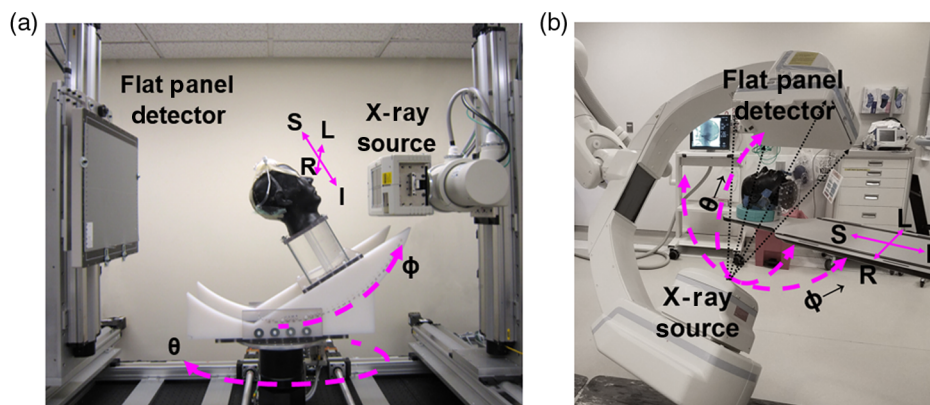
Experimental platforms for task-driven imaging. (a) CBCT test bench with rotational platform and manual tilt stage. (b) The robotic C-arm system. In each system, the source–detector trajectory is defined by a series of N source locations containing two DoFs: rotation angle θ and tilt angle ϕ . The patient’s right (R), left (L), superior (S), and inferior (I) directions are indicated in the rotating coordinate frame of the patient on the test bench and in the world reference frame for the C-arm.
